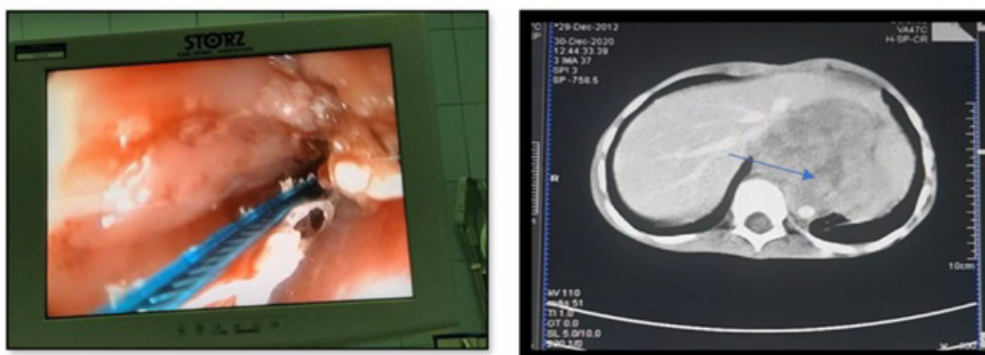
Endoscopic view of distal esophageal shows adherent mass and severe stenosis (on the left) and CT revealing a large mass between abdomen and mediastinum (on the right)
